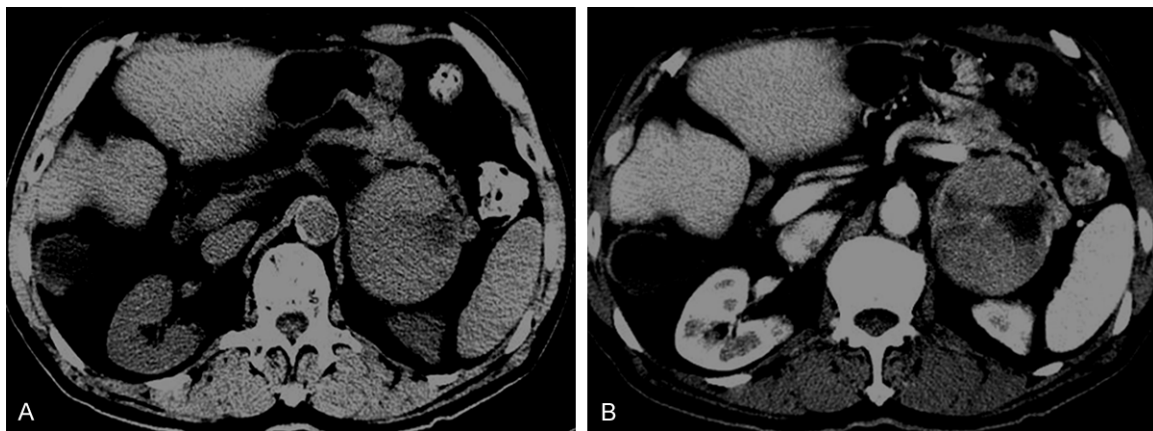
A 49-year-old female with cortisol producing adenoma of the left adrenal gland. A. The mass shows heterogeneous attenuation with patchy low attenuation area on non-enhanced CT. B. The mass presents moderately heterogeneous enhancement after contrast administration.
